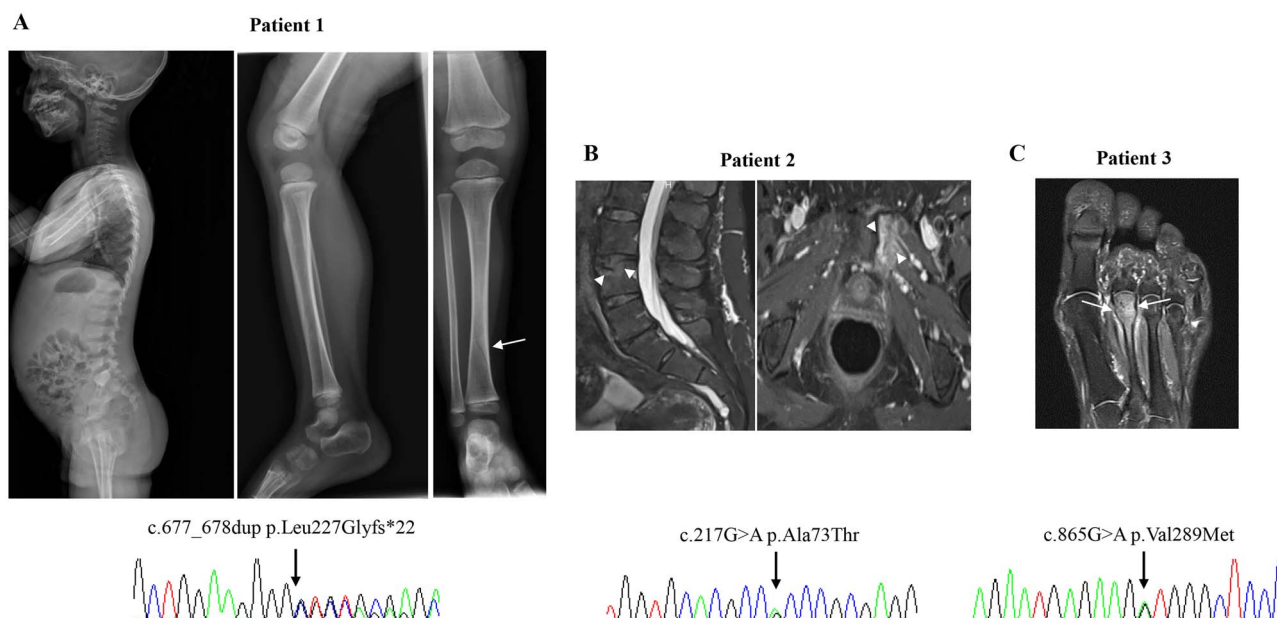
Imaging and electropherogram of the patients. (A) Patient 1: 3-year-old boy. X-rays of spine show diffuse osteopenia without vertebral fractures. X-rays of tibia revealed diffuse osteopenia with thin cortical long bones, with a non-displaced spiral fracture of the diaphysis of the right tibia (white arrow) and Sanger sequencing chromatogram. (B) Patient 2: 51-year-old woman. Mild fracture of L4 upper vertebral endplate associated with intracancellous herniation on MRI (Oct 2019) and bone-marrow edema as mild hyperintensity on STIR images (white arrowheads) and Sanger sequencing chromatogram. (C) Patient 3: 61-year-old woman. Multiple fractures of the metatarsus with bone-marrow edema (white arrows) and Sanger sequencing chromatogram.
